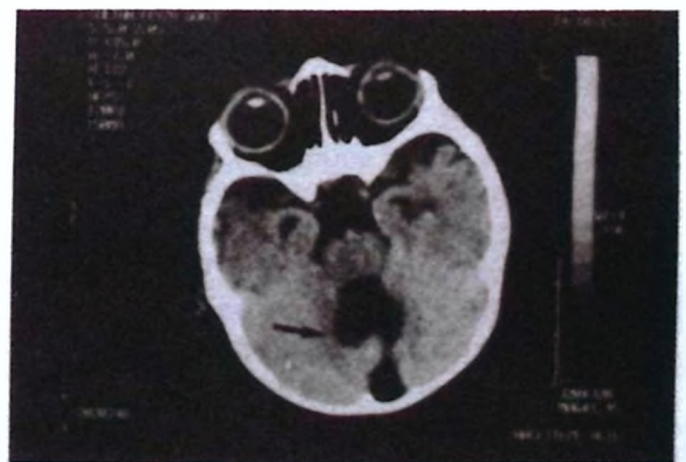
Brain computed tomography (CT) demonstrates large fourth ventricle with hypoplasia of vermis indicating Dandy-Walker variant (arrow).
